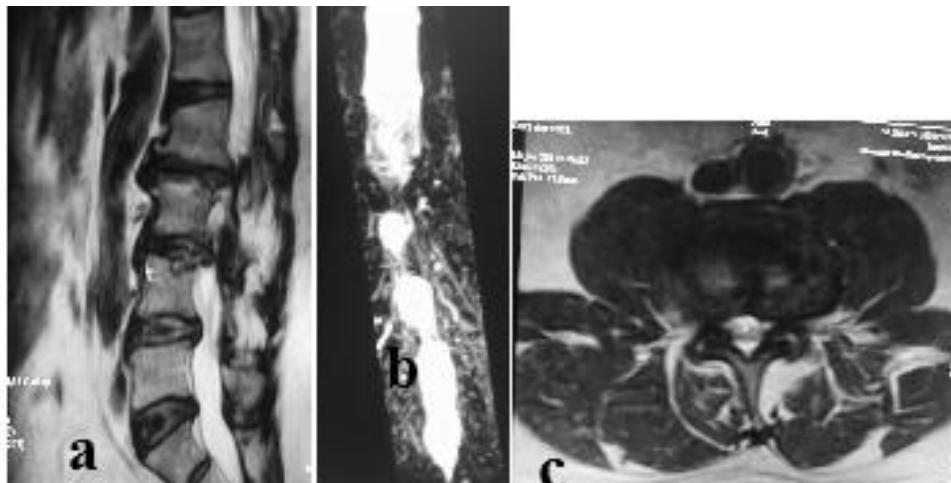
MR imaging of spinal cord compression. a. Sagittal T2-weighted imaging. b. T2-weighted MR myelogram of same patient showing extramedullary mass blockage of the dural space and cord compression. c. Transverse MR imaging showing severe nerve root narrowing of the patient.
